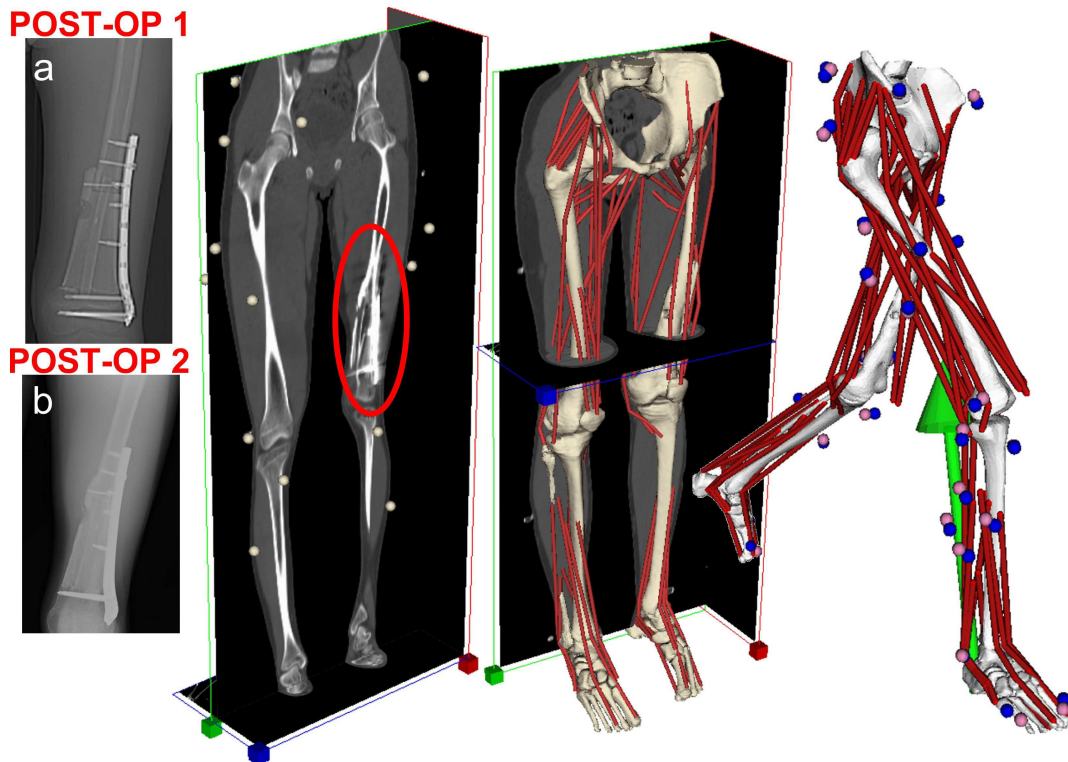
From left to right: RX of the reconstructed femur immediately after surgery (a) and after removal of distal screws (b); the lower limbs CT exam at month 31 of follow-up with the gait analysis markers visible; the musculoskeletal model superimposed on the CT data (LHPBuilder®, B3C, Italy); the musculoskeletal model in an intermediate frame of a gait cycle (OpenSim 1.9).
